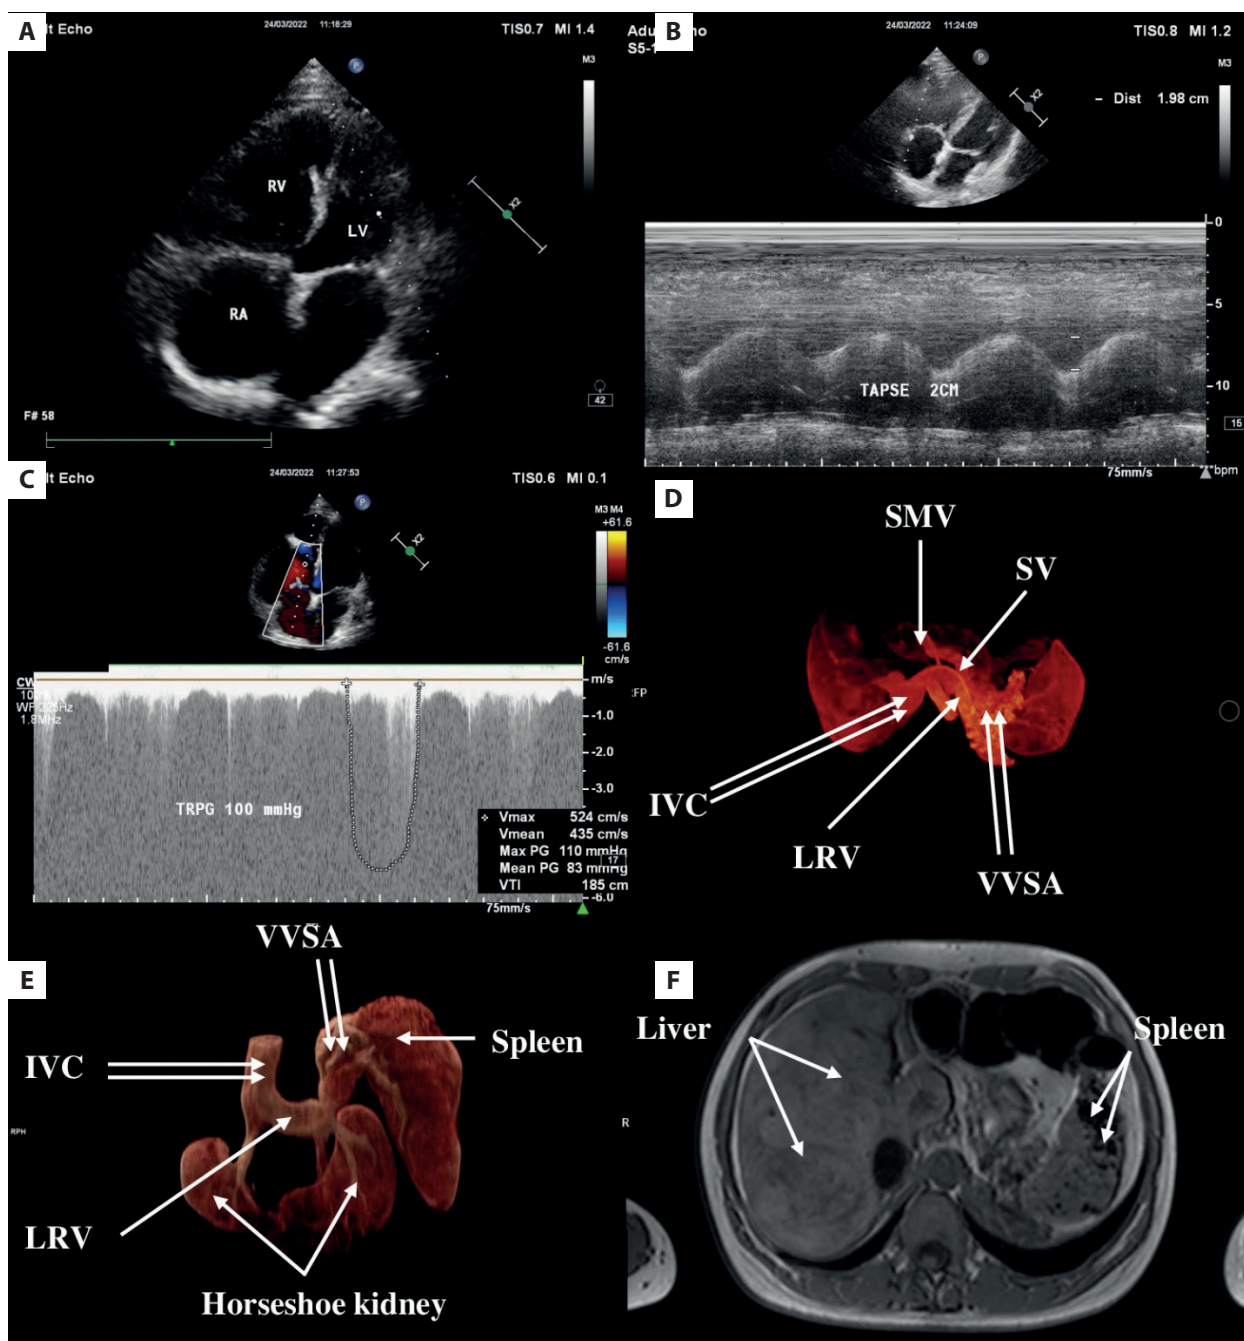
A. Echocardiography — TTE 2D modified 4C: visible enlargement of the RA and RV cavities with displacement and bulging of the RV towards the LV. B. Echocardiography — TTE M-mode: TAPSE calculation. C. Echocardiography — TTE CD: significantly elevated TRPG ~100 mm Hg. D. Magnetic resonance 3D volume rendering of T1-weighted contrast-enhanced subtraction images: SMV (single solid arrow) connects with the SV (single dropped arrow) and flows through the VVSA (double solid arrow) into the IVC (double dashed arrow) through the dilated LRV (single dashed arrow); neither the true trunk of the portal vein in the area of the hepatic hilum nor its intrahepatic branches are visible. E. Magnetic resonance 3D volume rendering of T1-weighted contrast-enhanced subtraction images: numerous varicose-shaped venous vessels of the collateral circulation are visible in the area of the splenic hilum (double solid arrow), draining into the significantly dilated LRV (single dashed arrow) and then to the IVC (double dashed arrow); horseshoe kidney also visible (double dropped arrow). F. Magnetic resonance — MRI axial T1 weighted image: heterogeneous, nodularly remodeled liver parenchyma (dashed arrows) and spleen with dilated venous lacunae (solid arrows)
